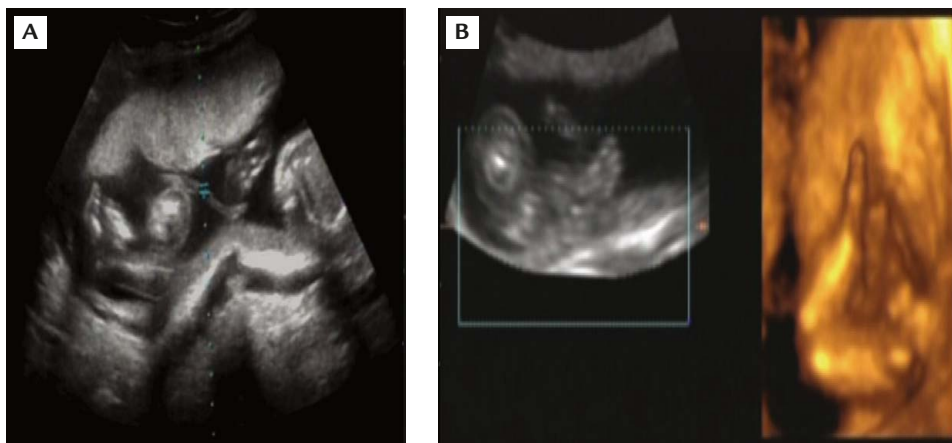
(A) Ultrasound shows twin pregnancy with the normal twin at about 20 weeks' gestation and an amorphous acardiac twin with one lower limb (femur length, 27 mm), and a single placenta in a singleton sac. (B) Four-dimensional ultrasound reveals a lower limb.
